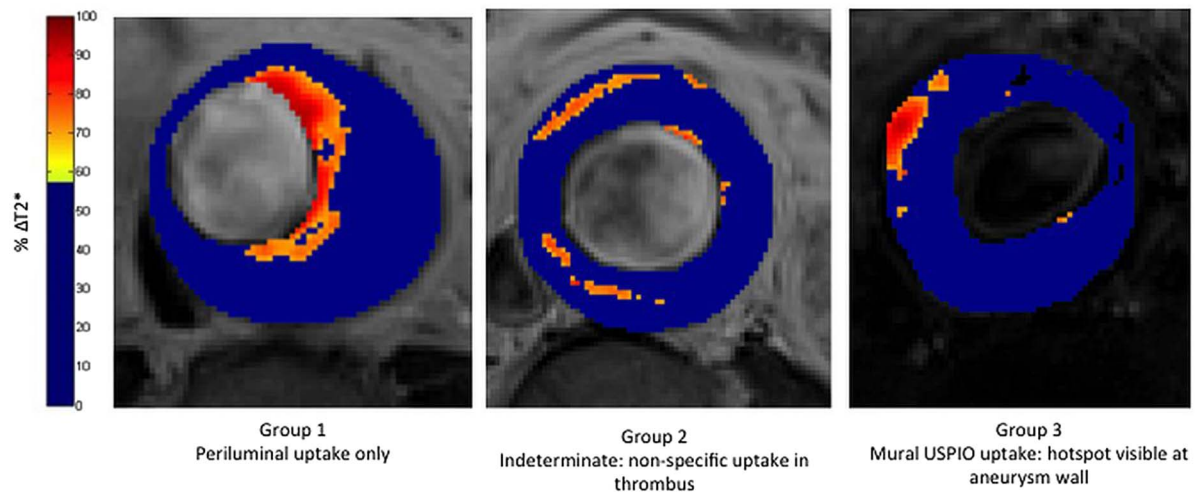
Magnetic resonance imaging (MRI) using ultrasmall superparamagnetic particles of iron oxide (USPIO) in abdominal aortic aneurysm disease. This technique is currently being investigated in the MA³RS study (MRI in Abdominal Aortic Aneurysms to Predict Rupture or Surgery—ISRCTN76413758).
